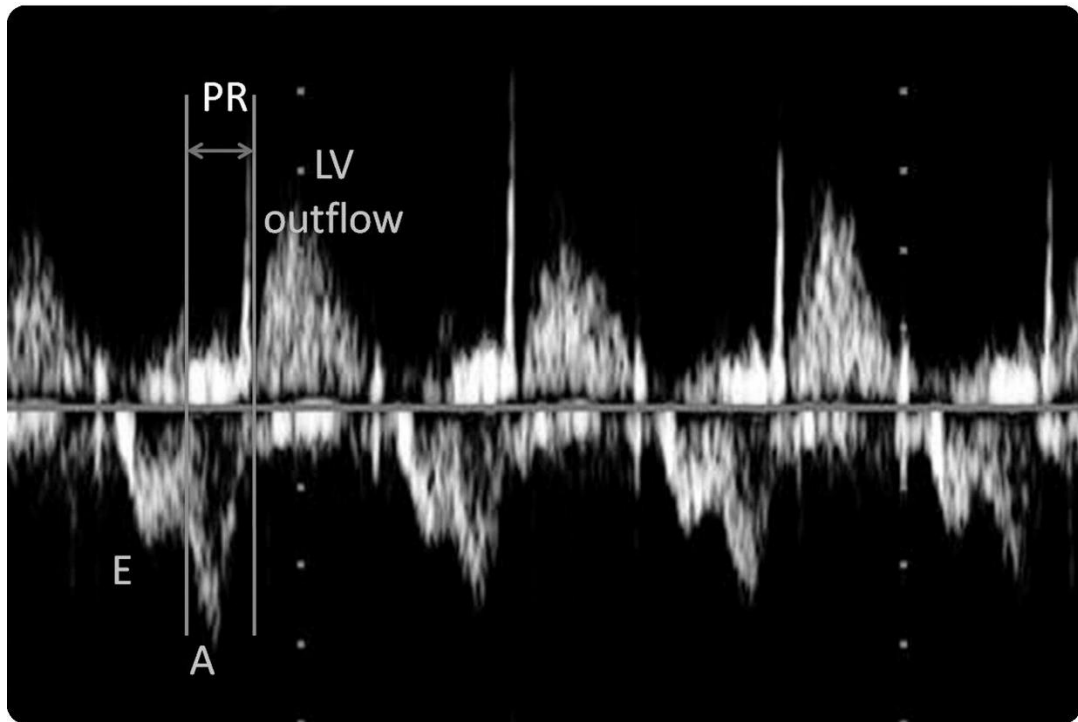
Figure taken from Stehlow et al. depicting a pulsed doppler tracing of combined mitral inflow and aortic outflow waveforms used to detect PR interval length in their study. The mechanical PR interval, which is shown between the 2 vertical lines, begins at the start of the A wave and ends at the initiation of systole. (Stehlow et al., 2010)
